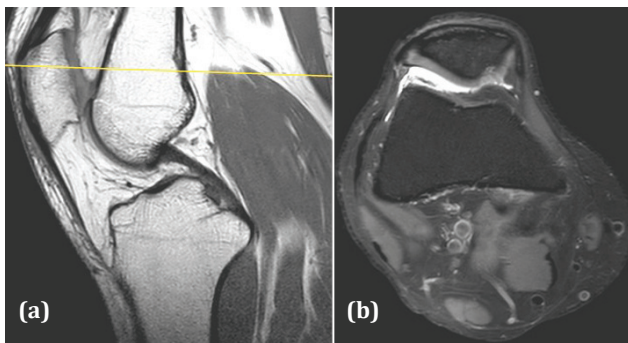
MRI on right knee (a) T2 sagittal image and (b) axial proton density fat-saturated image revealing grade-IV chondromalacic changes in the medial patellar facet (Flip angle: 90°).
